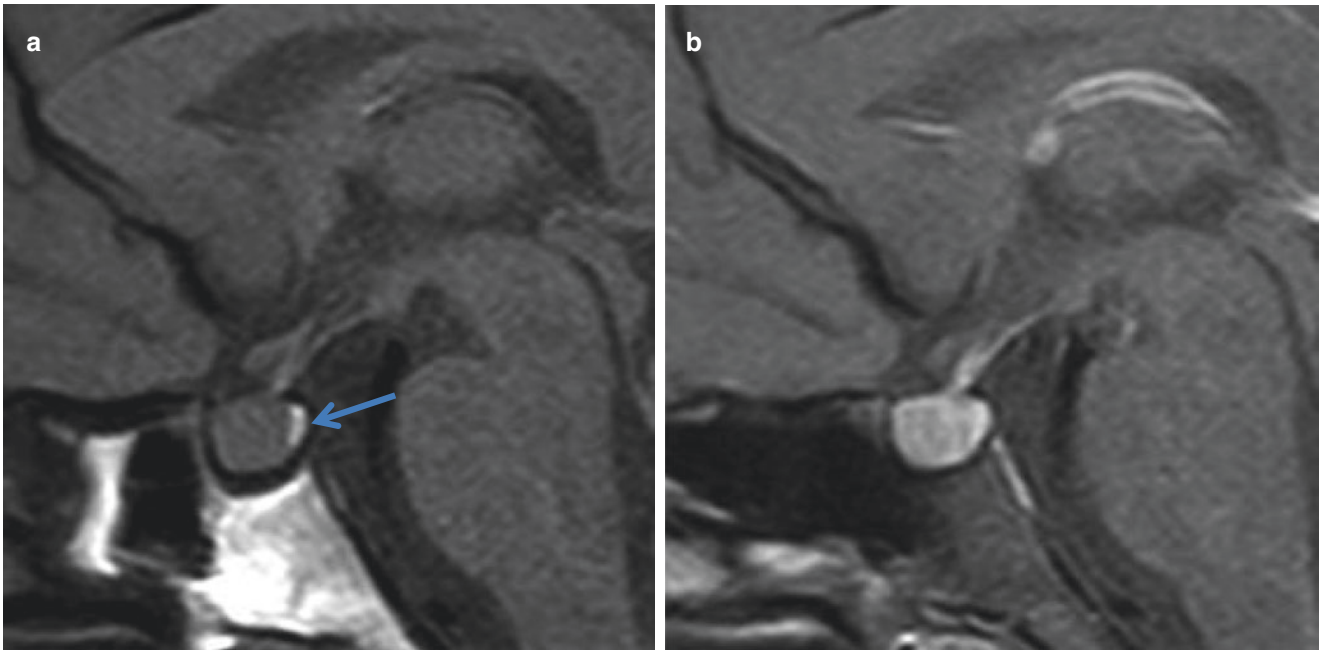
Normal neurohypophysis anatomy. T1-weighted sagittal images pre- and post-contrast. The *arrow* points to the spontaneous bright neurohypophysis, located at the sella turcica posteriorly. After the injection of IV gadolinium, the entire gland exhibits an intense enhancement
